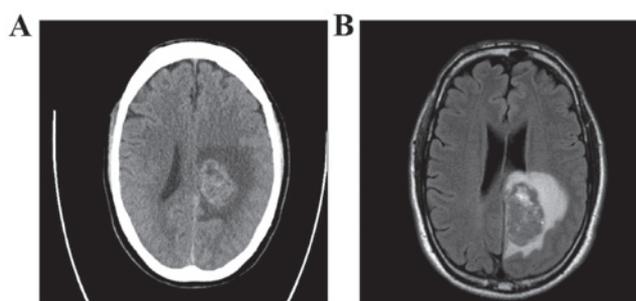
Radiological examination. Preoperative (A) Computed tomography and (B) magnetic resonance imaging with contrast enhancement of the brain, showing a lesion sized 5x3 cm in the left occipital lobe, with associated edema.
